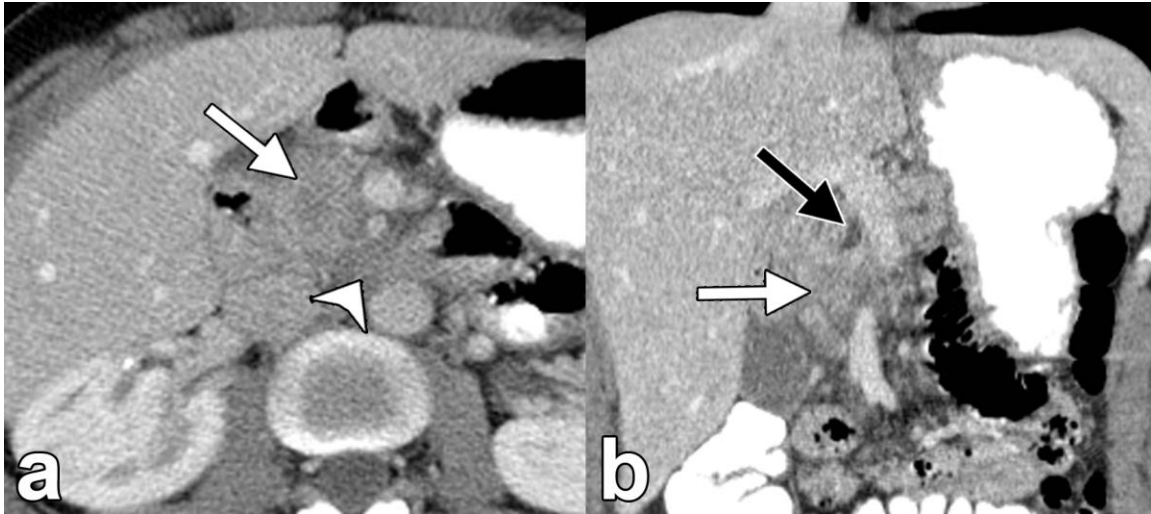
Example of an indeterminate CT examination. A 39 year-old woman underwent uniphasic contrast-enhanced CT for evaluation of abdominal pain for 2 weeks and elevated lipase. (a) Axial and (b) coronal images show an ill-defined hypoattenuating region in the pancreatic head (white arrows). There is effacement of fat surrounding the superior mesenteric vessels (arrowhead) and the pancreatic duct is dilated upstream to the pancreatic head (black arrow). Imaging findings were interpreted as possible pancreatitis, however, an MRI was recommended (not shown) and a pancreatic adenocarcinoma was diagnosed on that study.
